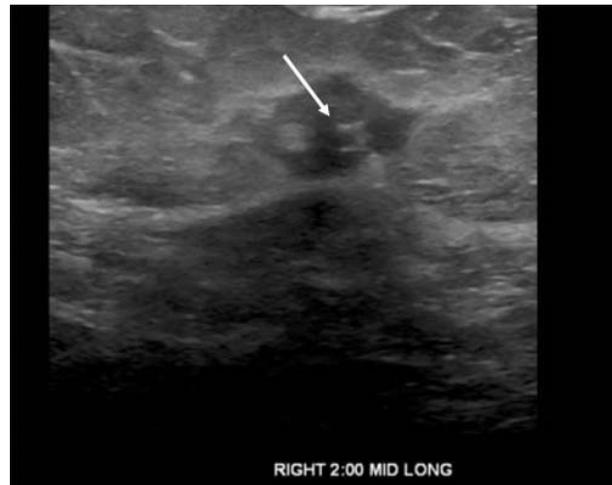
Sonogram at 6 months after cryoablation demonstrates the 2 o'clock mass as a poorly defined hypoechoic area with a central biopsy clip (white arrow). The halo of increased density noted immediately after cryoablation has resolved.
